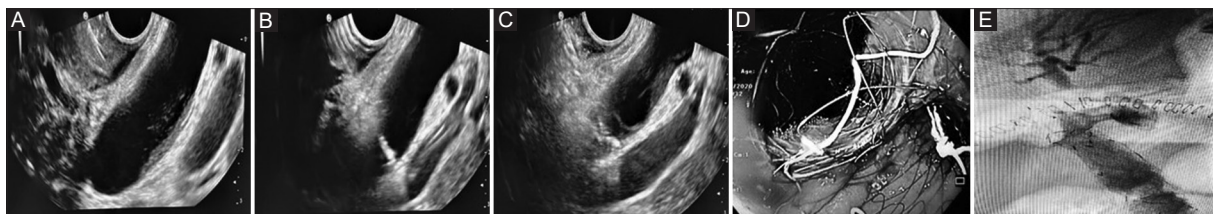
(A) Endoscopic ultrasound image showing dilated choledochal biliary duct (CBD); (B) puncture of the CBD; (C) deployment of distal flange of a lumen-apposing metal stent in the CBD lumen; (D) endoscopic check after stent placement; (E) final cholangiography with regular biliary outflow
